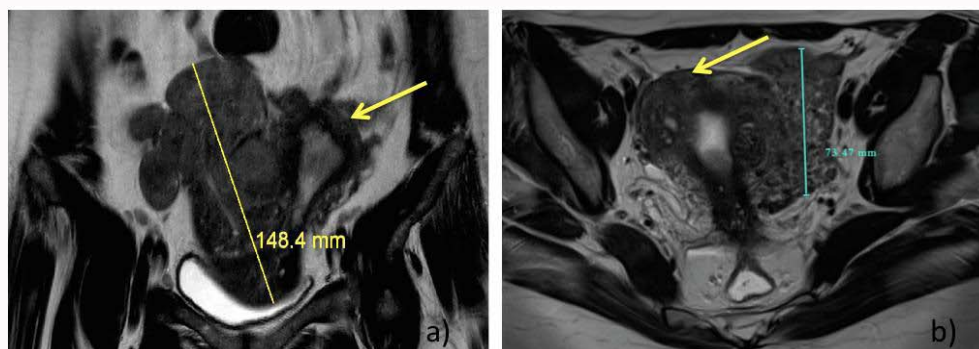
Pelvic MRI on T2-weighted images. a) Case 1: Coronal section, the bulky uterine masse bulges in the pelvic cavity, displacing the uterine body (arrow). b) Case 2: Axial section, the polylobulated uterine masse next to the uterine body (arrow) infiltrates the broad ligament.
